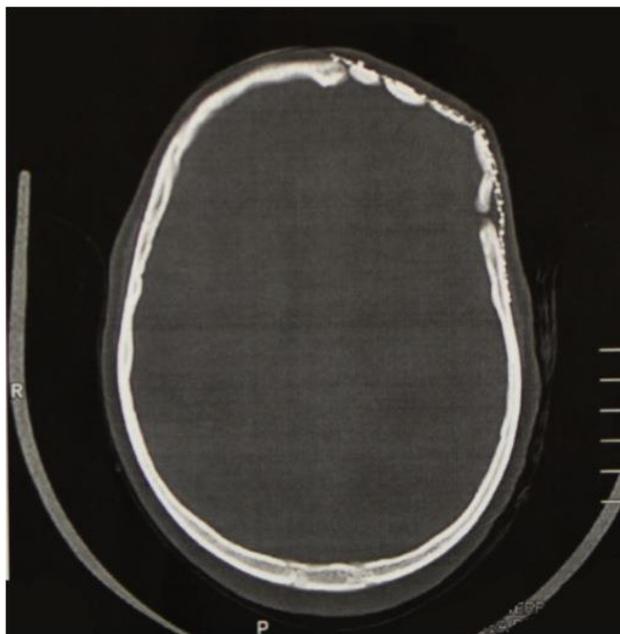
Computed tomography showing restoration of the facial morphology after one year and 6 months follow up in axial cut.
